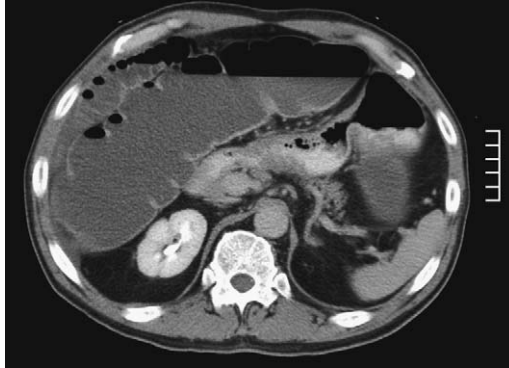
Axial, contrast-enhanced CT scan shows markedly dilated, fluid-filled large bowel consistent with obstruction.
